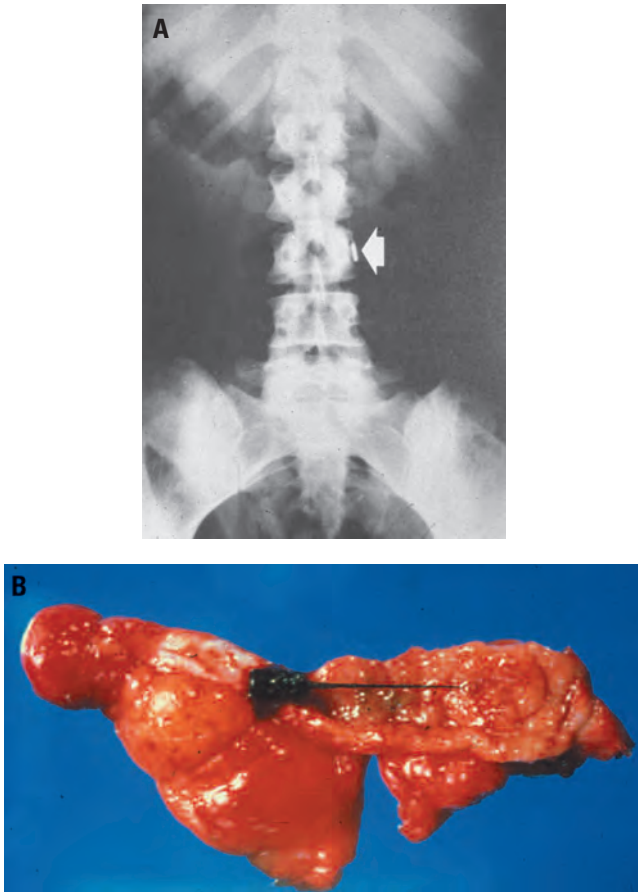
A, Abdominal radiograph of a swallowed endodontic instrument now caught in the duodenum. It must be removed surgically. Courtesy of J. Goultchin and B. Heling. B, Swallowed endodontic file that ended up in the appendix and led to acute appendicitis and appendectomy. The use of a rubber dam would have prevented this tragedy. Courtesy of L. C. Thomsen and colleagues.
